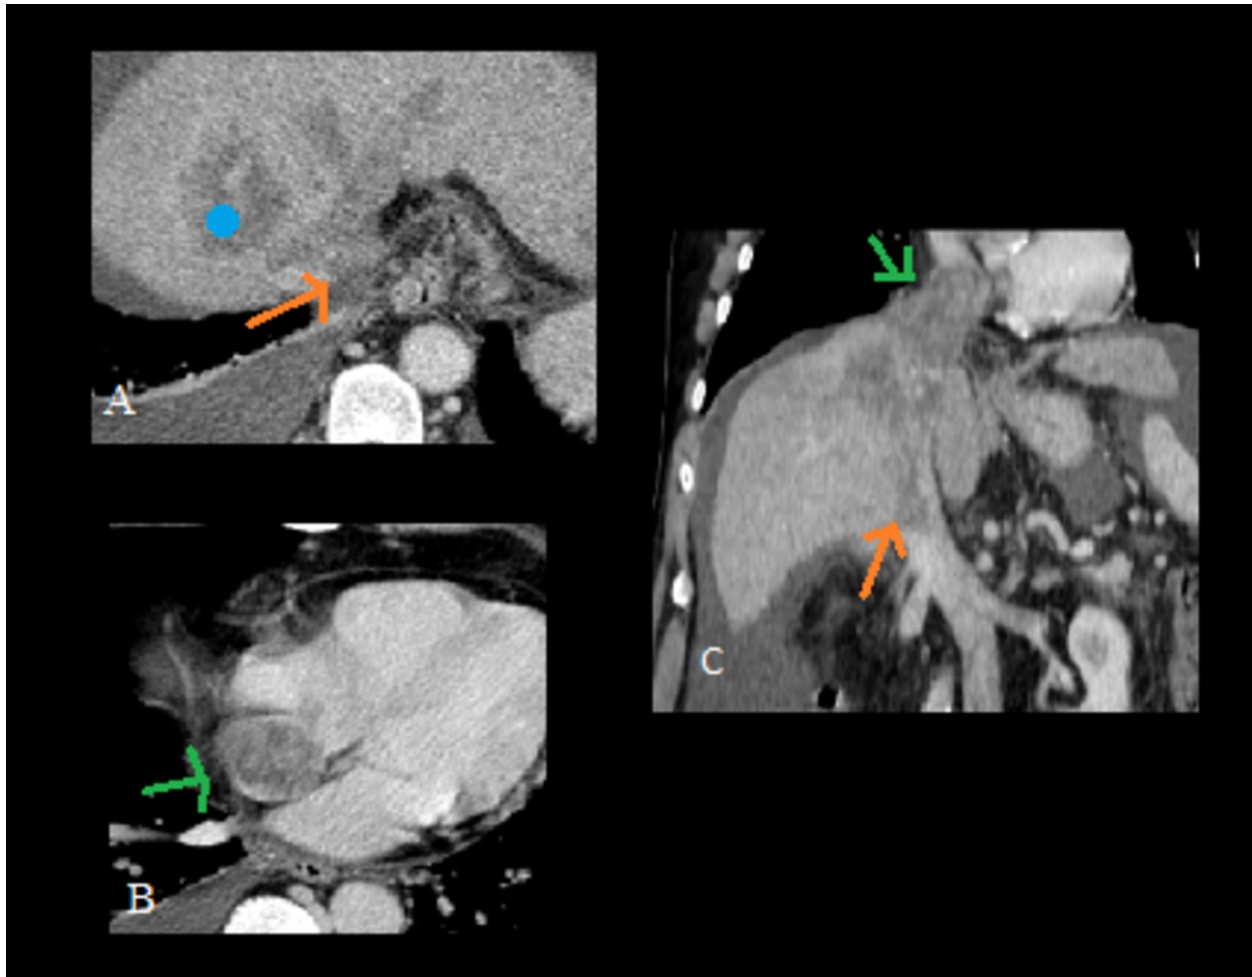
Malignant IVC thrombosis: Contrast CT scans reveal a large HCC (blue dot) extending to the IVC (orange arrow) and right atrial appendage (green arrow).
